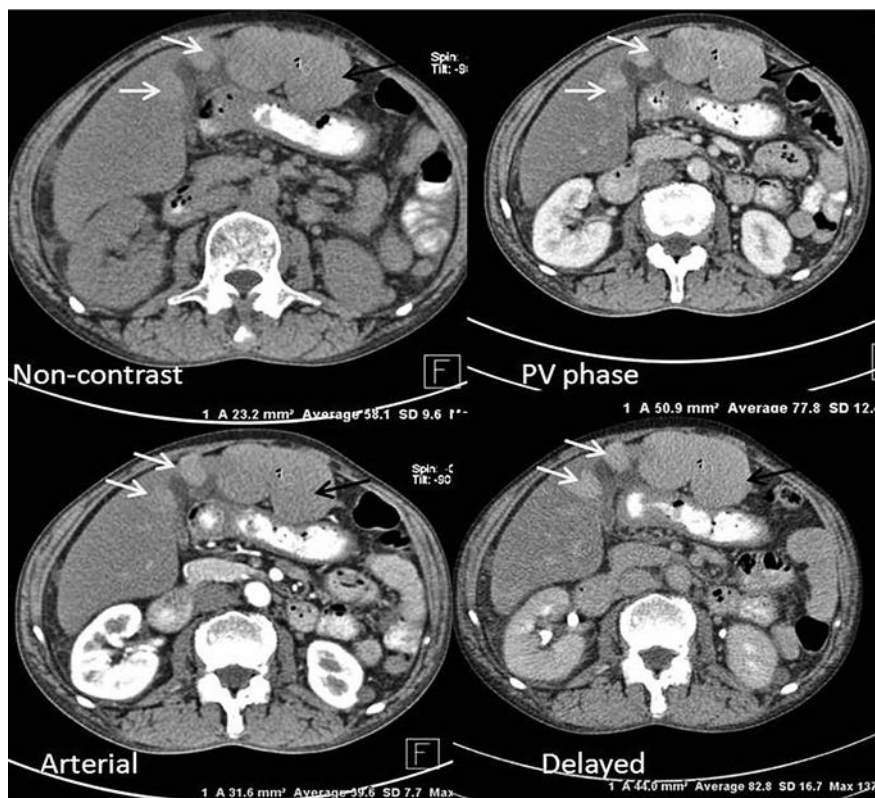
Dedicated multi-phasic axial CT sections of the liver: nodular areas (white arrows) with increasingly dense enhancement in portal venous and delayed phases. Few of the lesions (black arrows) are exophytic, especially in the left lobe. The rest of the abdomen - unremarkable.
